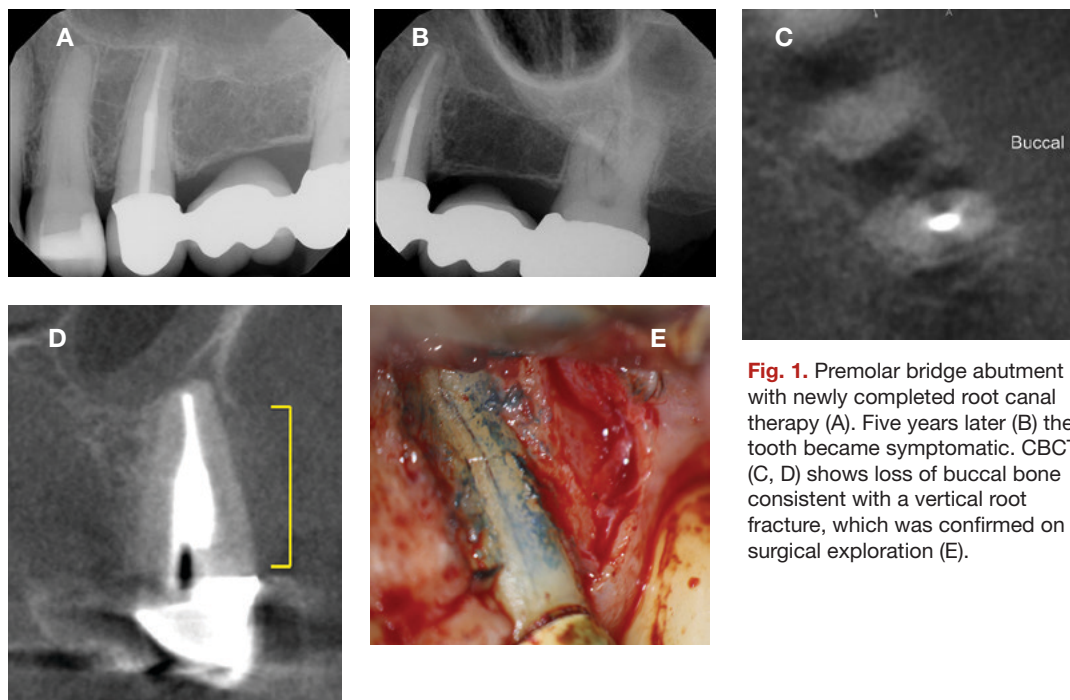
Premolar bridge abutment with newly completed root canal therapy (A). Five years later (B) the tooth became symptomatic. CBCT (C, D) shows loss of buccal bone consistent with a vertical root fracture, which was confirmed on surgical exploration (E).
